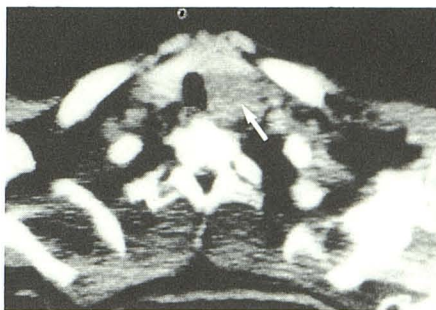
Patient 1. Axial noncontrast CT scan shows left thyroid lobe and a portion of the isthmus to be enlarged (arrow) with decreased attenuation compared with normal-appearing right thyroid lobe. There is no invasion of the trachea, and surrounding tissue planes are well maintained.
